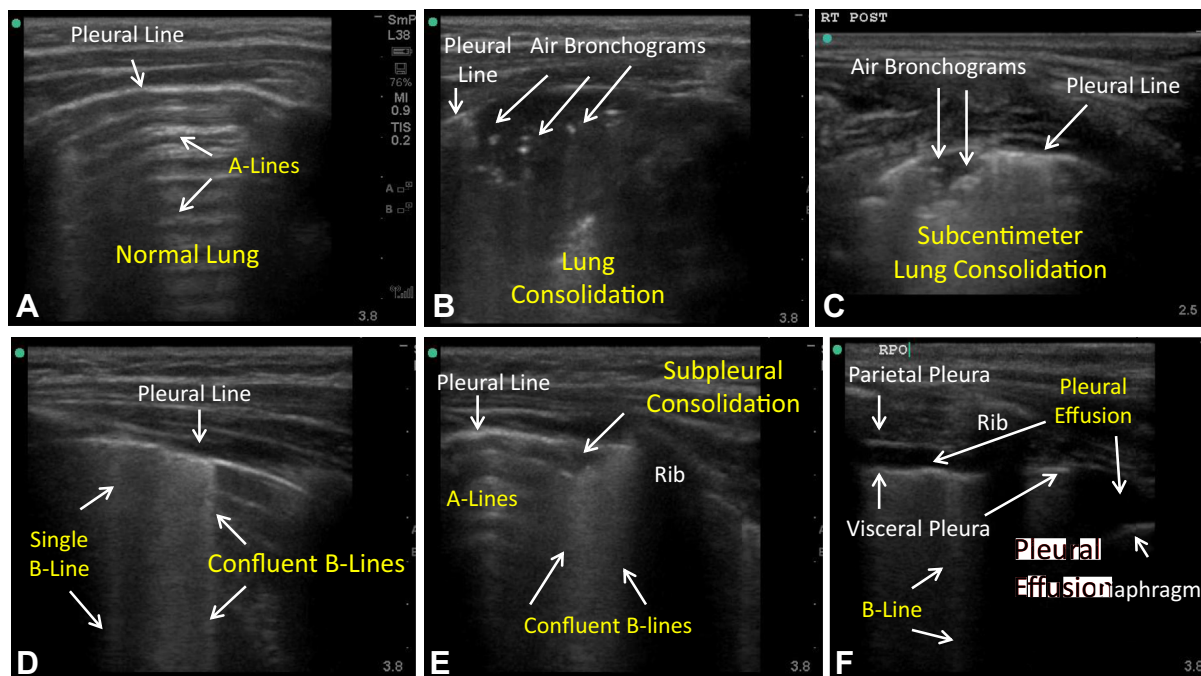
Lung ultrasonographic images. A, Normal lung (A-lines). B, Focal pneumonia, radiographically apparent ( $\geq 1$  cm lung consolidation with air bronchograms). C, Focal pneumonia, radiographically occult ( $< 1$  cm lung consolidation with air bronchograms). D-E, B-lines, confluent B-lines, subpleural consolidation more commonly associated with viral pneumonia or bronchiolitis; note subpleural consolidations ( $< 0.5$  cm) without sonographic air bronchograms visible. F, Pleural effusion (anechoic space between lung and chest wall or diaphragm).
